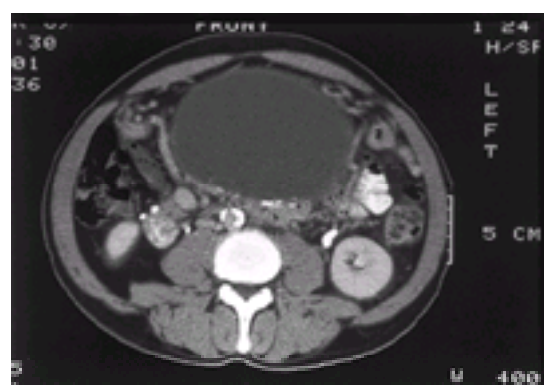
Large intra-abdominal abscess demonstrated by CT; it may be easily drained percutaneously.
